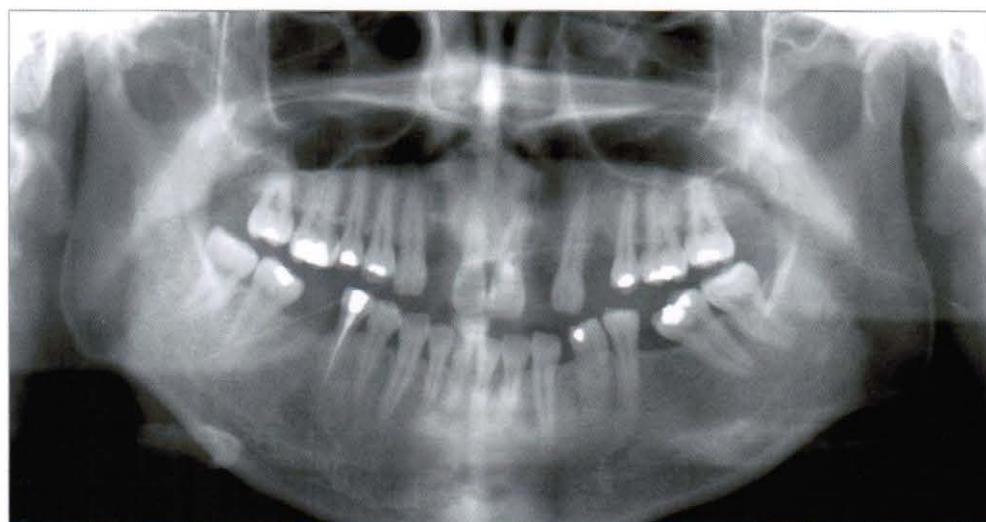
Pre-treatment panoramic radiograph. All the retained roots have been extracted. The lower left second molar is mesially tilted. The lower right second molar shows slight mesial tilting.
